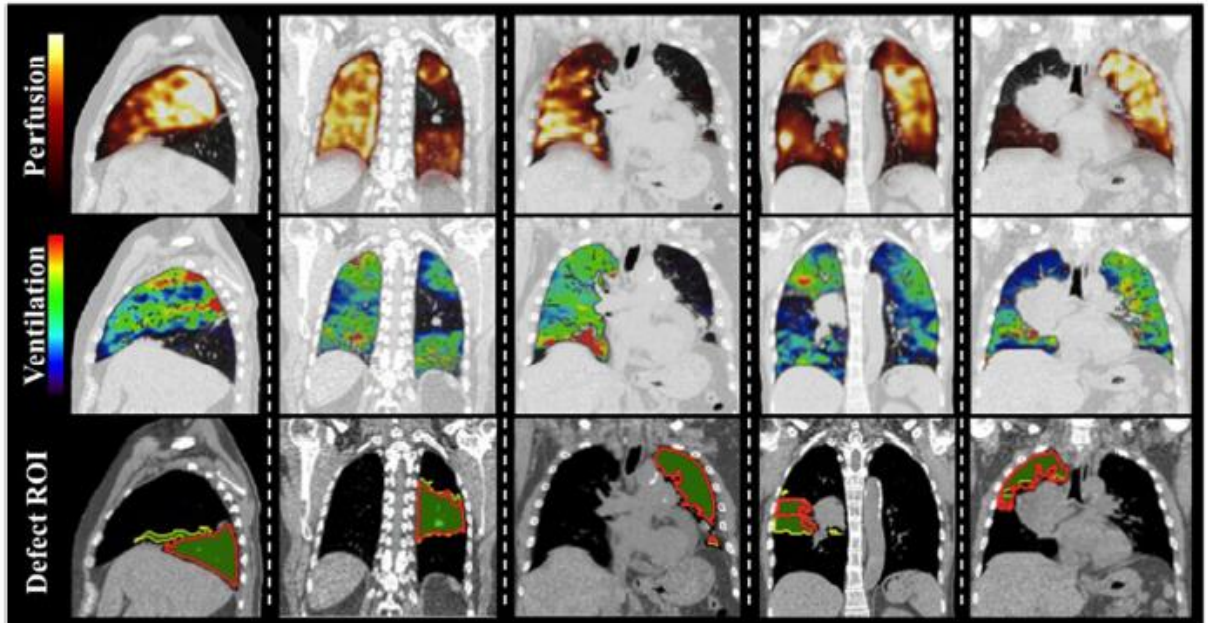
Comparison of SPECT perfusion (top row) with 4D-CT ventilation (middle row) for five patients with malignant airway disease. Reproduced with permission from Castillo *et al.* (2012).
